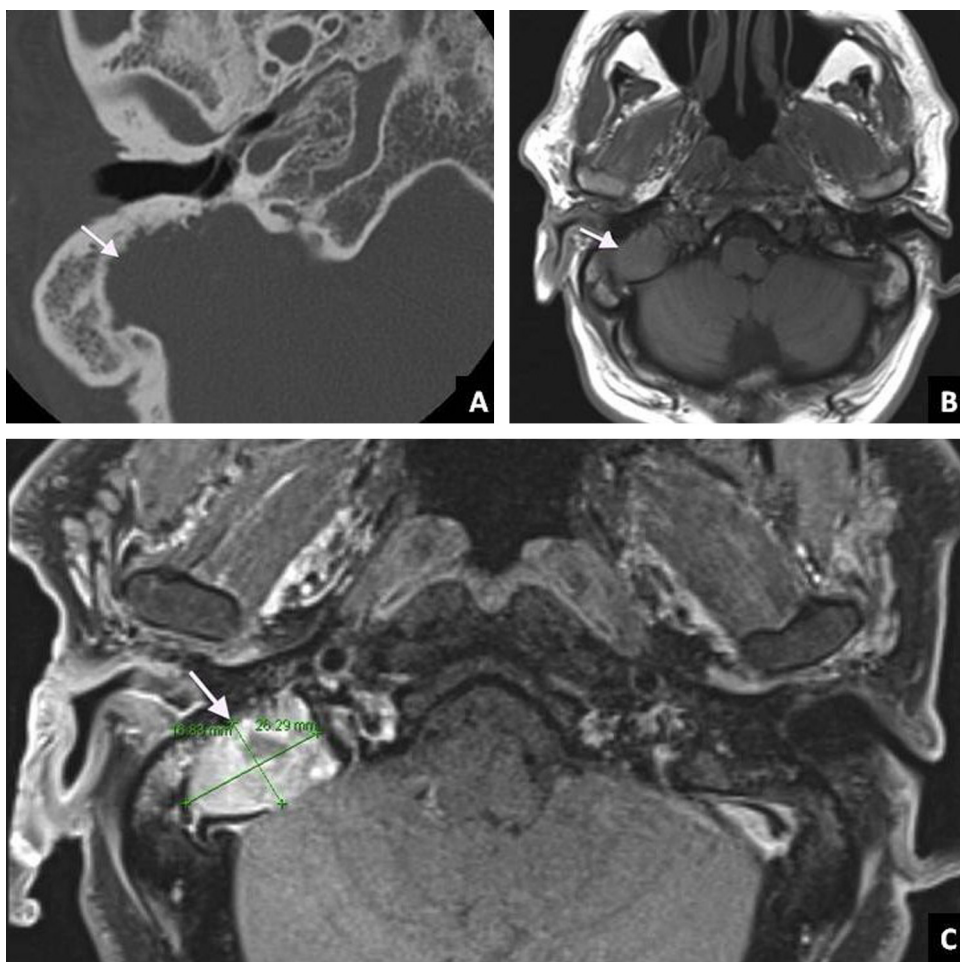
Right temporal bone CT, axial slices (A); axial T1-weighted cerebral MRI without gadolinium injection, through the temporal bone (B); axial T1-weighted cerebral MRI with gadolinium injection, through the temporal bone (C).
